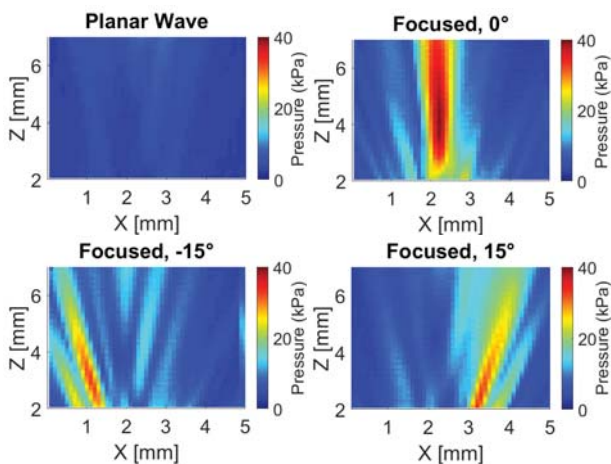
Measured ultrasound beam profiles.
